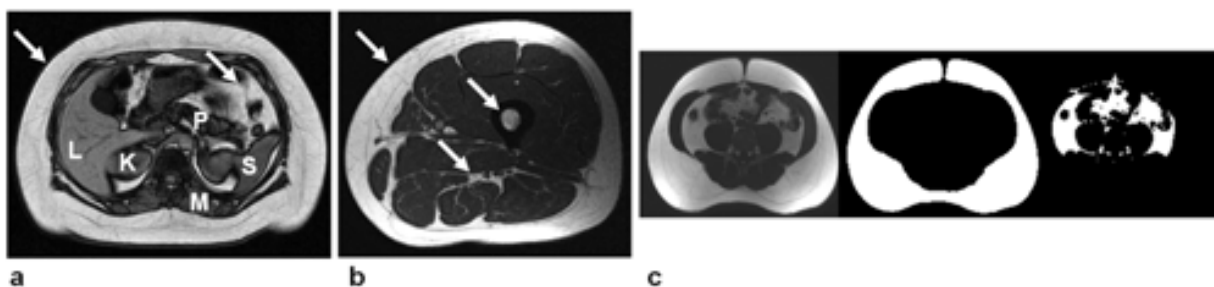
$T_1$ -weighted MRI. Examples in the (a) abdomen and (b) thigh, demonstrating the high signal intensities of fat *in vivo* (arrows: SAT, VAT, bone marrow, intermuscular fat) in contrast to darker muscles and organs (L: liver, P: pancreas, K: kidneys, M: muscle, S: spleen). (c) A high signal intensity threshold of an abdominal  $T_1$ -weighted image easily identifies fat pixels. Intensities with values below the set threshold are “discarded” and set to zero. For well-optimized  $T_1$ -weighted pulse sequences, this simple step can be quite robust in identifying abdominal SAT (middle) and VAT depots (right).
